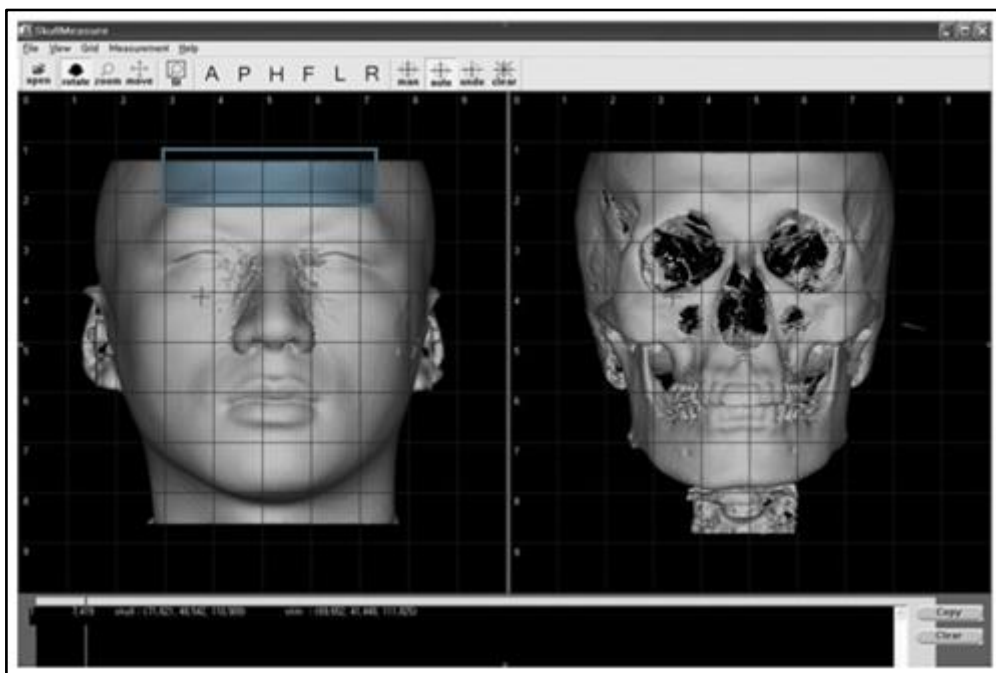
A window of the Skull Measure program utilized to measure facial soft tissue (ST) depths from cone-beam CT images [3]
